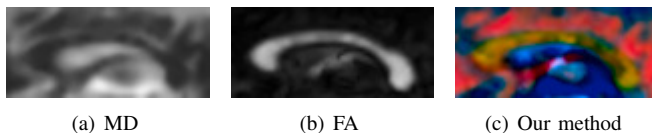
Close up on the CC. Note how the fornix appears with the same color as the CC body when either MD or FA are used (as well as in the structural MR image in Fig. 7). Using our method, the fornix appears with a different (reddish) color, whereas the CC body appears yellowish reflecting the differences in the underlying DTs and connectivity patterns. The coloring is according to the legend in Fig. 5.
